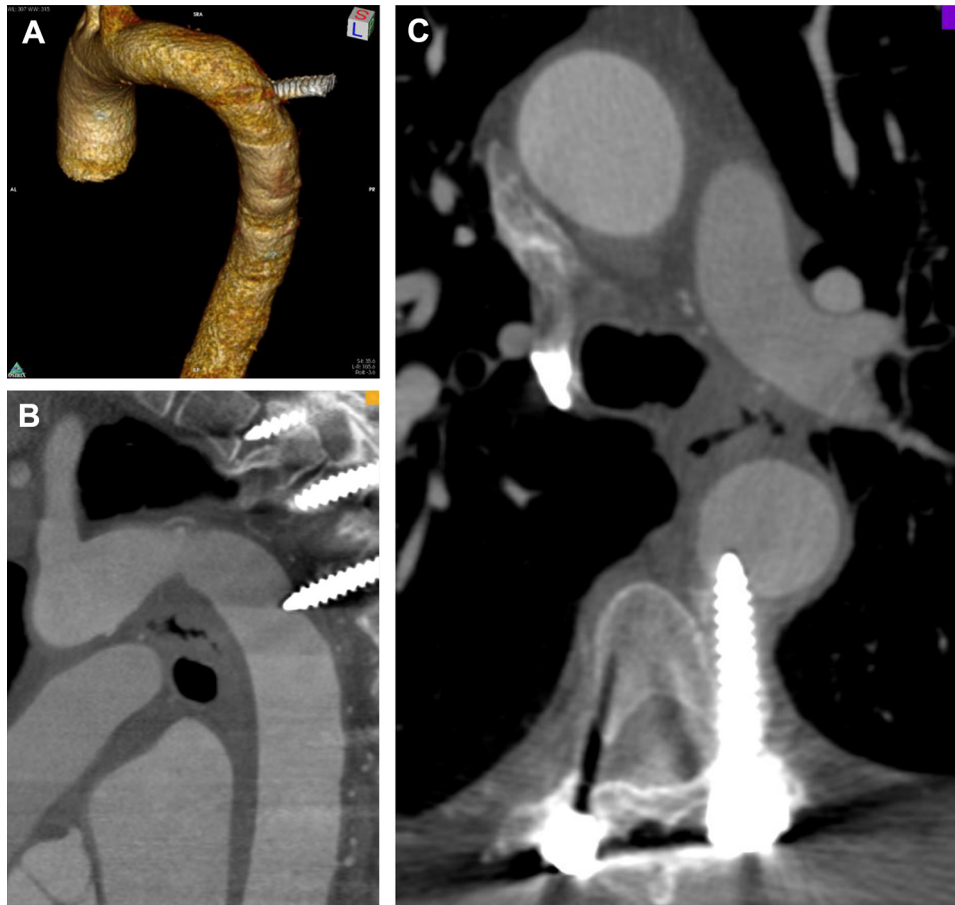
Three-dimensional reconstruction (A) of the aortic perforation at the level of the third thoracic vertebra. Sagittal (B) and transverse (C) views of the aortic injury on computed tomography (CT).
